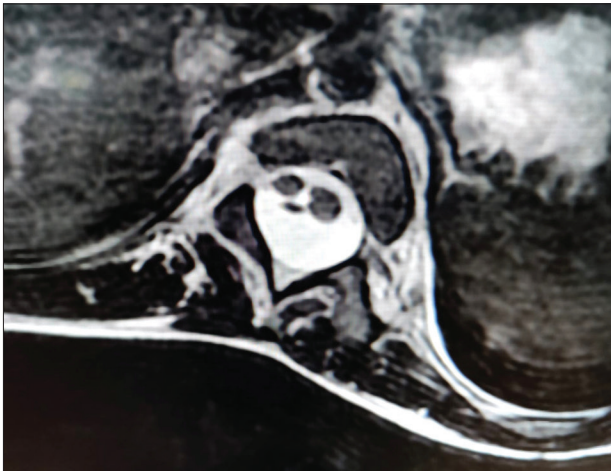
Axial magnetic resonance imaging dorsolumbar spine image at D10 level showing triplication of the spinal cord (triplomyelia).
